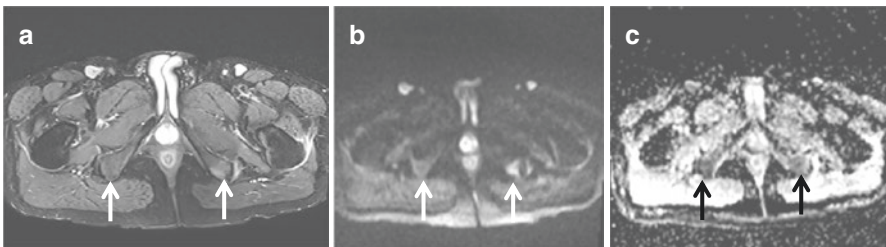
Bilateral (Left > right) ischial tuberosity enthesitis (a) shows STIR axial image with subtle edema visible only on left, (b) shows bright signal bilaterally on DWI and (c) shows altered diffusion bilaterally
